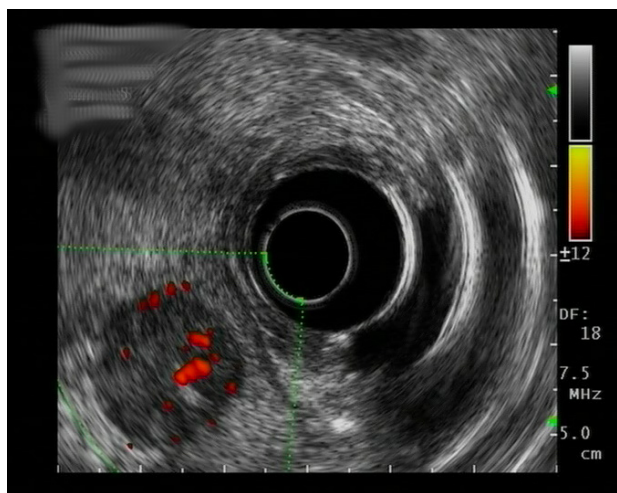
Typical image of pancreatic neuroendocrine tumour seen in radial endosonography (EUS). Small, 17 mm, hypoechoic, well-defined, and vascularized lesion
